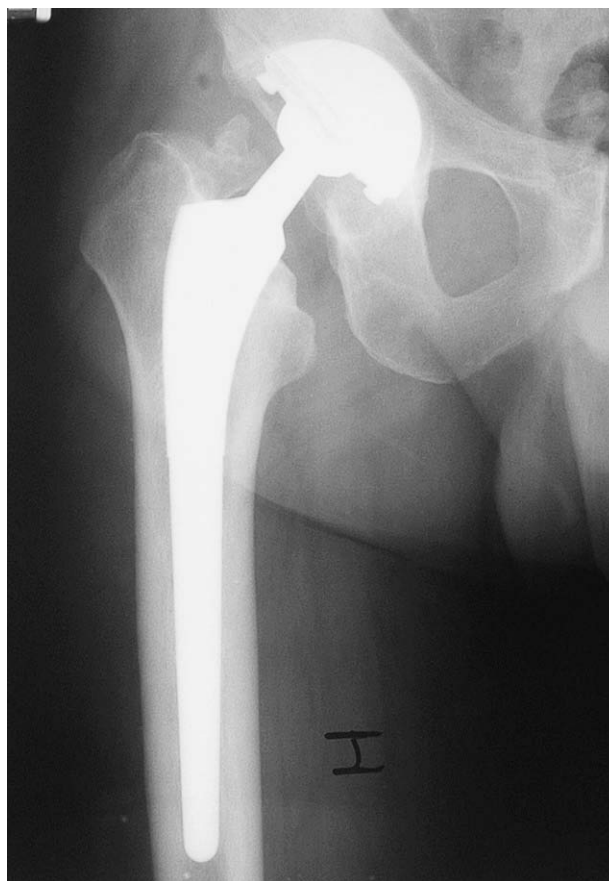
Antero-posterior x-ray of the M2a metal-on-metal bearing.
